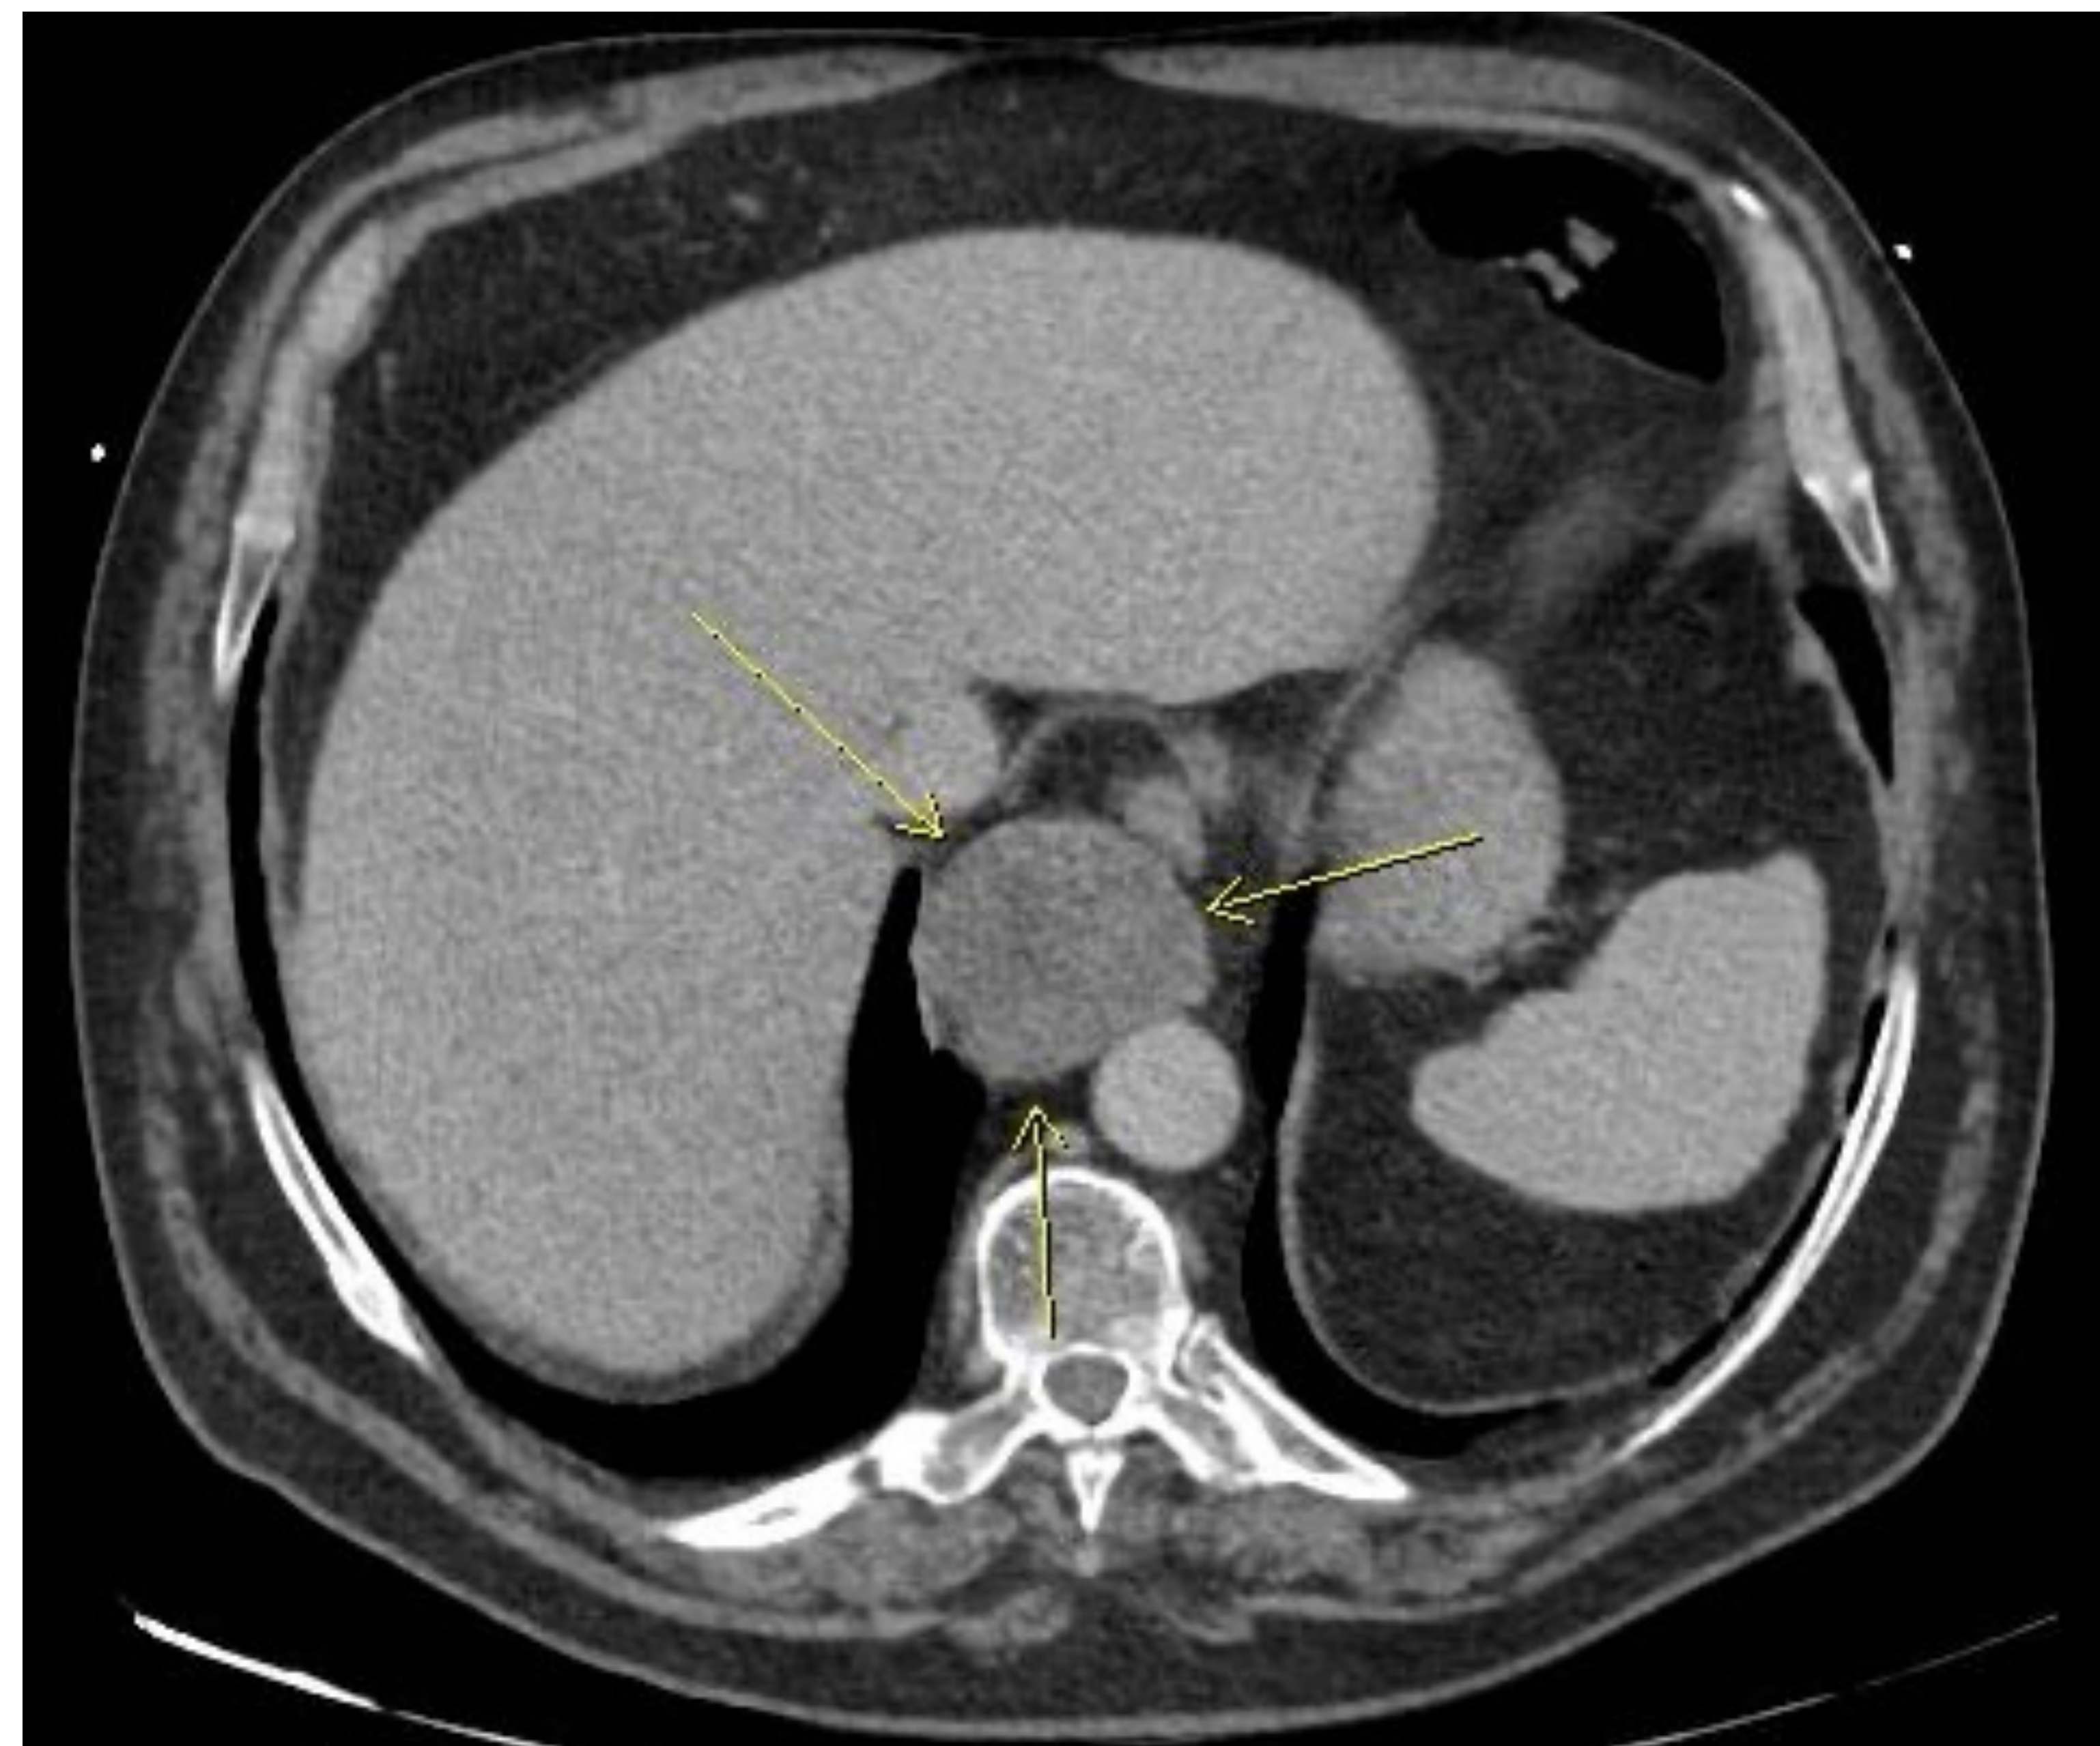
Transverse CT View of Paraesophageal GIST
